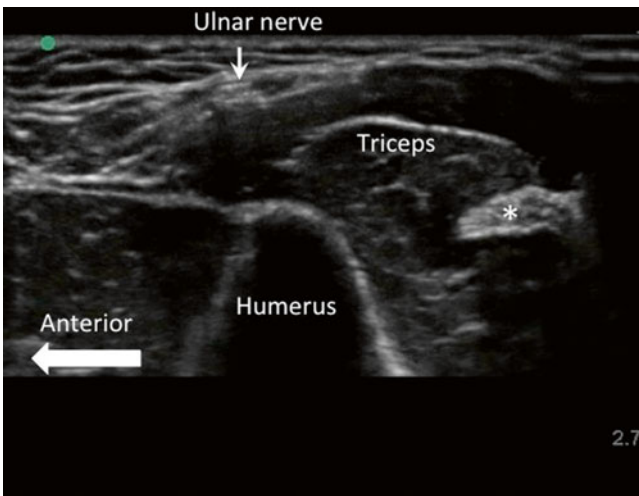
Sonogram of the ulnar nerve proximal to the cubital tunnel. The ultrasound probe is placed on the medial aspect of the arm. * Indicates the tendon of the medial head of triceps (Reproduced with permission from Philip Peng Educational Series)
